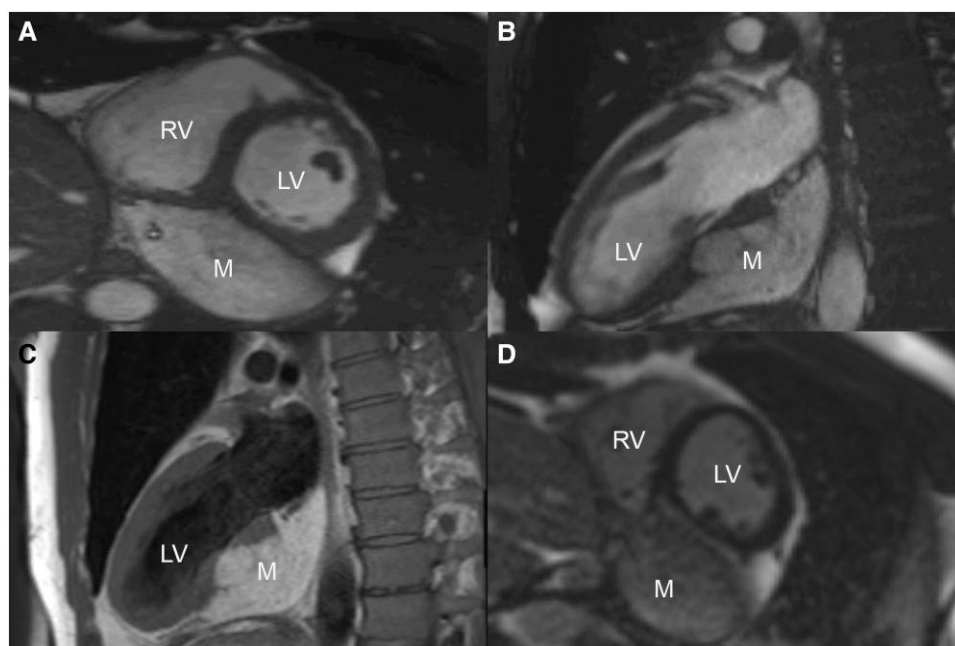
Cardiac structural MRI. (A) Short-axis at level of MV papillary muscles. (B) 2-chamber view. Demarcation of the epicardial mass (M) with myocardial infiltration and focal thinning of the mid-inferior wall. (C) T1-Weighted dark blood imaging demonstrating homogenous lipomatous tissue characterization of the epicardial mass. (D) LGE at epicardial tumour interface to myocardium at the inferior and inferolateral wall. See [Supplementary material online, Video S2](#).
